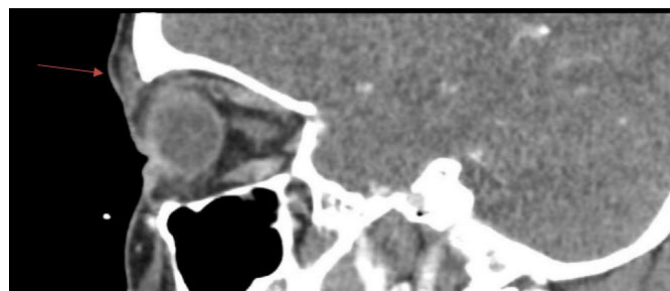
Sagittal CT orbits showed mild bilateral periorbital inflammation on presentation (arrow).
